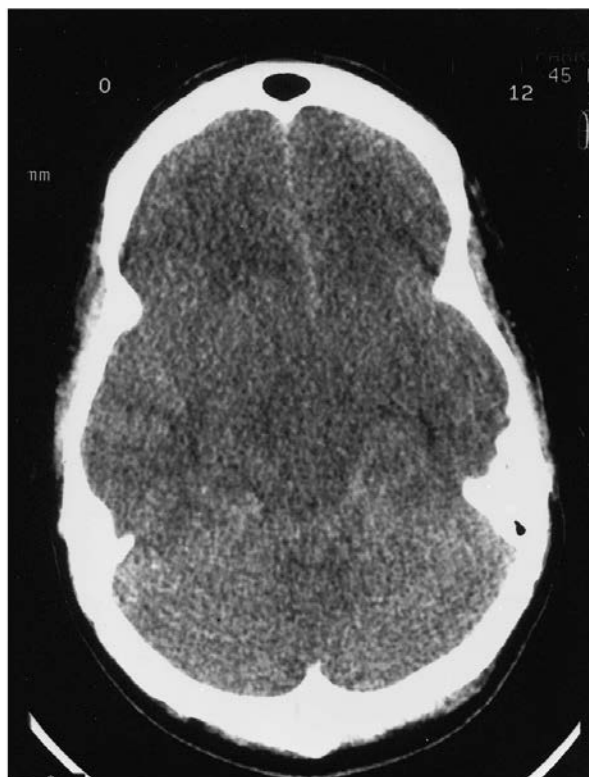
A head CT scan of a comatose 45-year-old man with central herniation syndrome. He had bilateral fixed and dilated pupils, secondary massive cerebral edema and intractable intracranial hypertension. The CSF spaces, especially the perimesencephalic cisterns are effaced.
